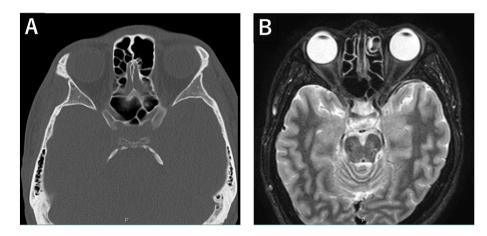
Imaging findings of the head at the first visit after injury. A: Computed tomography scan of the head. There is no abnormality, such as bone fracture of the optic nerve canal. B: Magnetic resonance imaging of the head. There is no abnormality, such as hematoma of the optic nerve canal.
